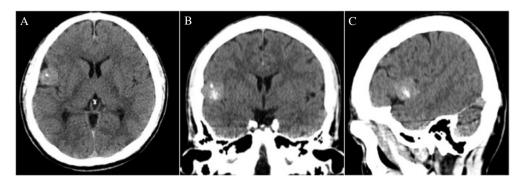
Plain axial (A), coronal, (B) and sagittal (C) computed tomography brain scans showing a 24 × 19 × 21 mm³ mass lesion in the right Sylvian fissure with calcification.
